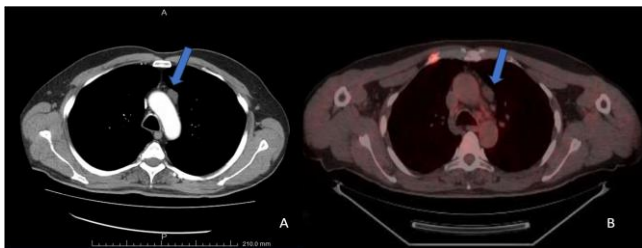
Lesion identifiable adjacent to the aorta on thorax CT (A), PET scan revealing the absence of metabolic activity in the lesion (B)
